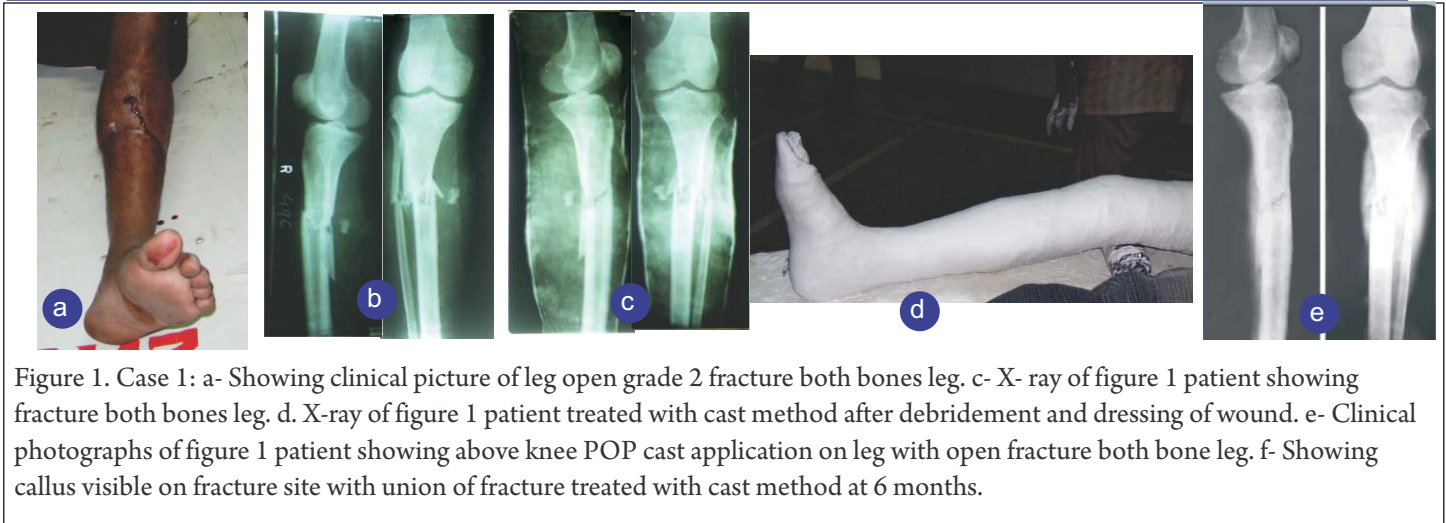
Case 1: a- Showing clinical picture of leg open grade 2 fracture both bones leg. c- X- ray of figure 1 patient showing fracture both bones leg. d. X-ray of figure 1 patient treated with cast method after debridement and dressing of wound. e- Clinical photographs of figure 1 patient showing above knee POP cast application on leg with open fracture both bone leg. f- Showing callus visible on fracture site with union of fracture treated with cast method at 6 months.
